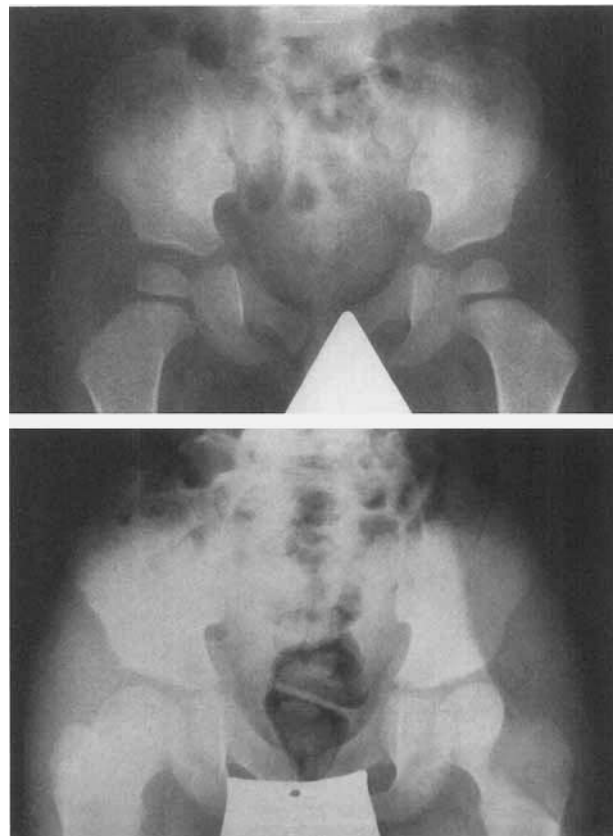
Patient 1, roentgenogram of the pelvis at age 3½ years (top) and 11½ years (bottom). Note short femoral necks in coxa valga position and steep acetabular roofs.
